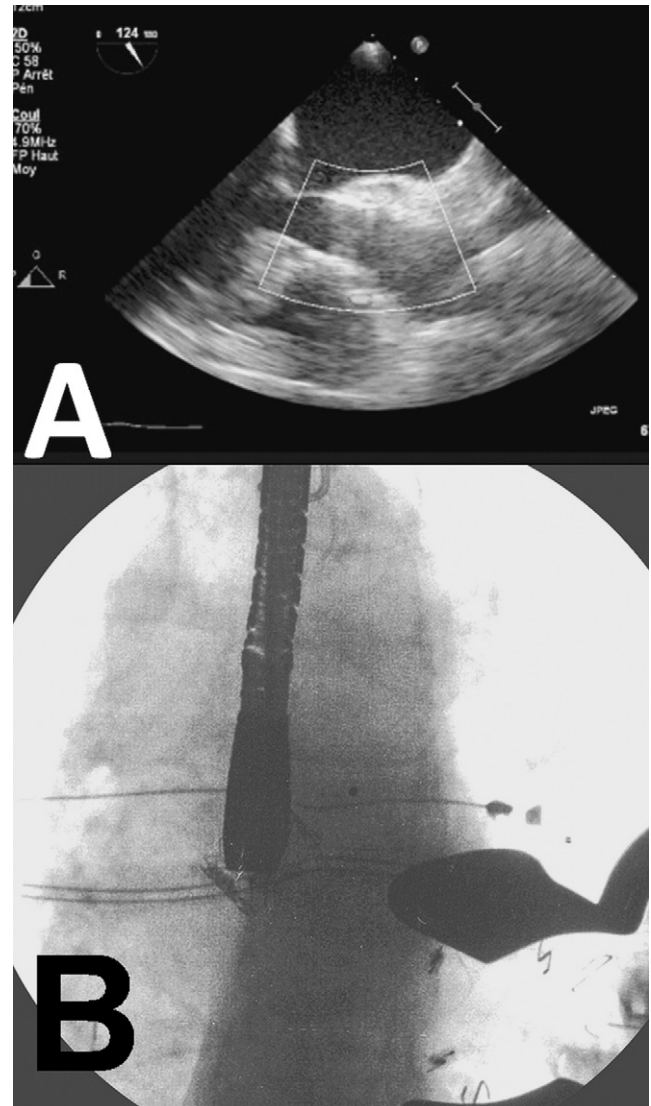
Intraoperative images from the trans-oesophageal echocardiogram (A) and from the C-arm fluoroscopy (B) confirming the perfect stent-valve positioning and deployment in the ideal landing zone.
